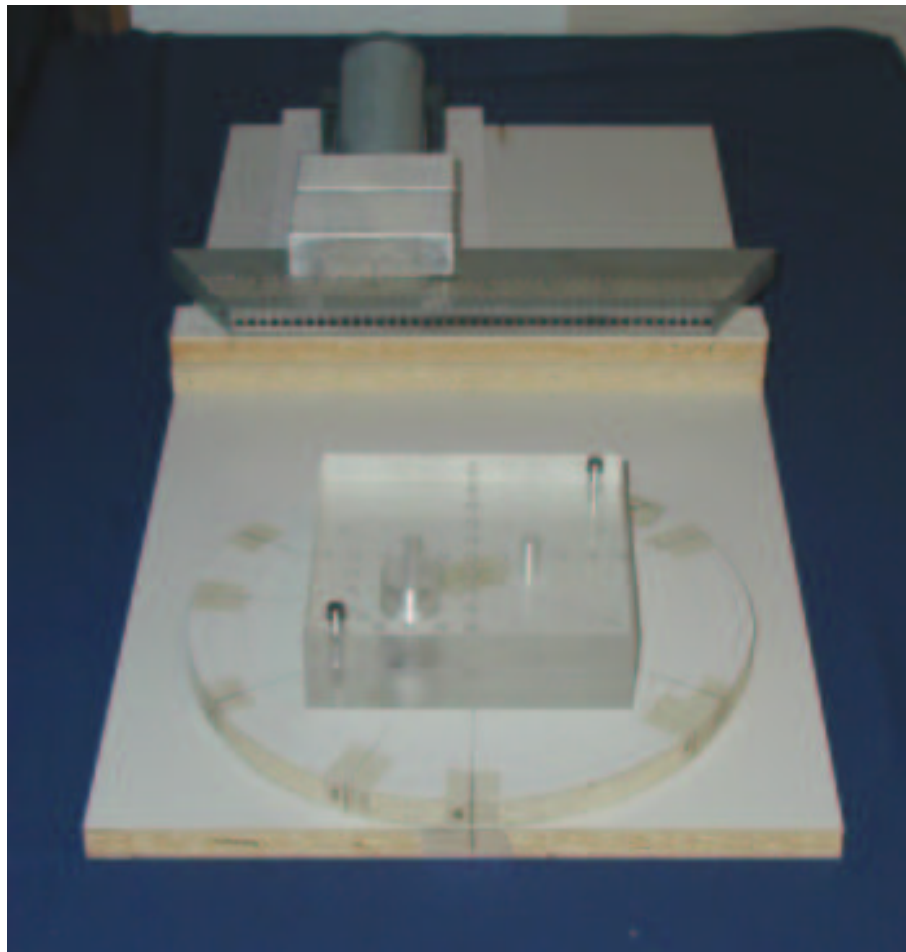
Field of view in 6P-SPECT is 28 cm wide. Detectable height at the center of rotation is 1.5 cm from the central plane.
